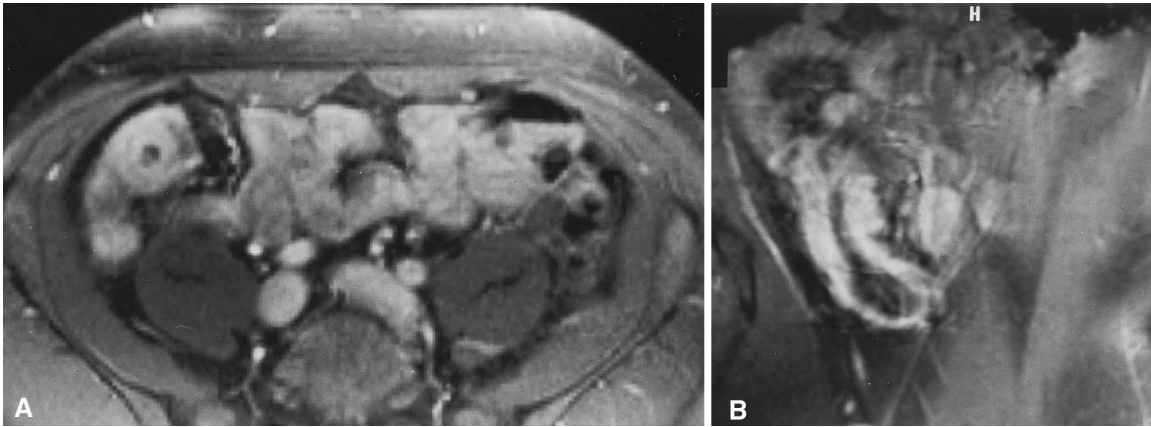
T1-weighted contrast-enhanced (A) axial and (B) coronal images with fat-suppression technique confirms the loop-in-loop or target lesion
